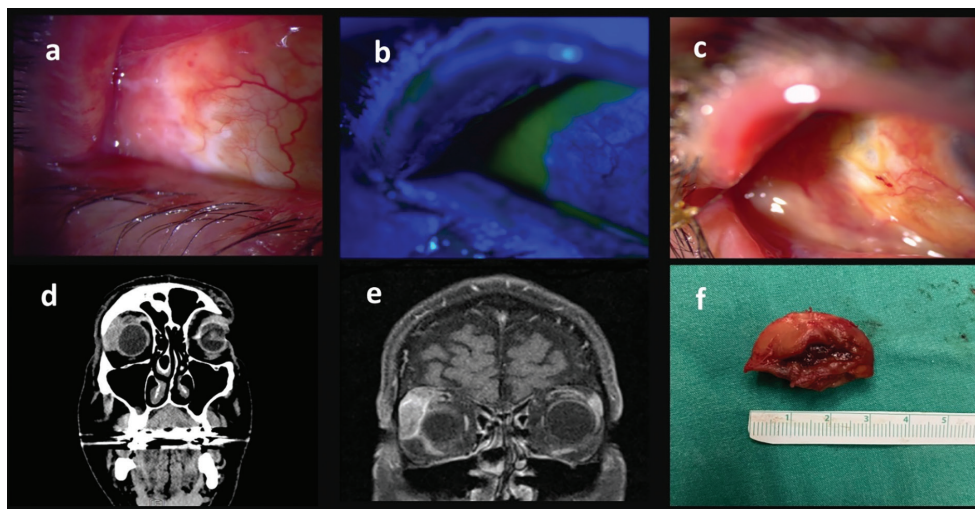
a) Slit-lamp anterior segment examination at presentation showed ciliary injection, marked erosion, and necrosis in the superotemporal quadrant of the bulbar and forniceal conjunctiva. b) After applying 1% fluorescein dye, the cobalt blue filter indicates necrosis in the superotemporal quadrant of the bulbar and forniceal conjunctiva. c) Hemorrhage, conjunctival necrosis, and scleral thinning in the region corresponding to the area where the enlarged palpebral lobe of the lacrimal gland makes contact, consistent with necrotizing scleritis. d) Coronal computed tomography scan of the orbit revealed an intraorbital mass located superotemporally, in the area corresponding to the lacrimal fossa, without any bony erosion. e) A coronal T1-weighted magnetic resonance image of the orbit showed a hyperintense orbital lesion in the lacrimal fossa. f) Excisional biopsy material measuring 30x20 mm was removed from the lacrimal fossa intraoperatively
